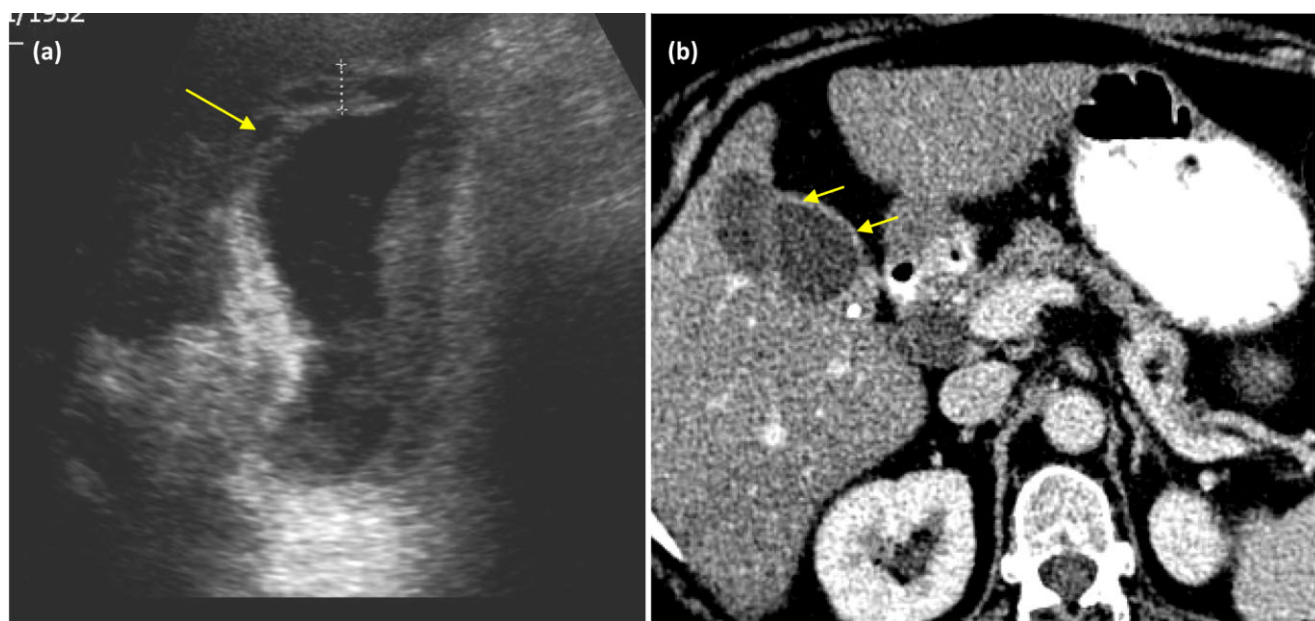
Imaging from patients with xanthogranulomatous cholecystitis (XGC). (a) An ultrasound scan demonstrating diffuse wall thickening (cursor) and intramural echogenic nodules (arrow). (b) Computed tomography (CT) post contrast image demonstrating continuous enhancement of the mucosal wall (small arrows)
